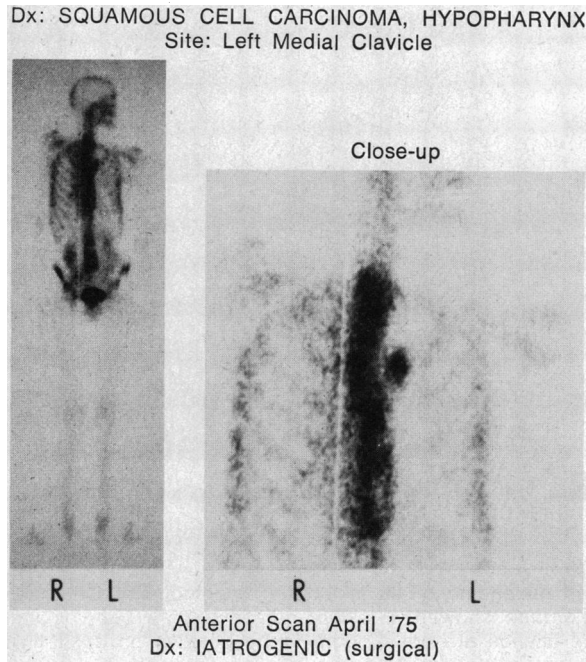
Bone scan of a 57-year-old man with squamous cell carcinoma of the hypopharynx. A single focus of increased radioactivity is visible in the left medial clavicle. No lesion was seen on the radiograph. In this patient radical dissection of the left side of the neck had been carried out before scanning.
